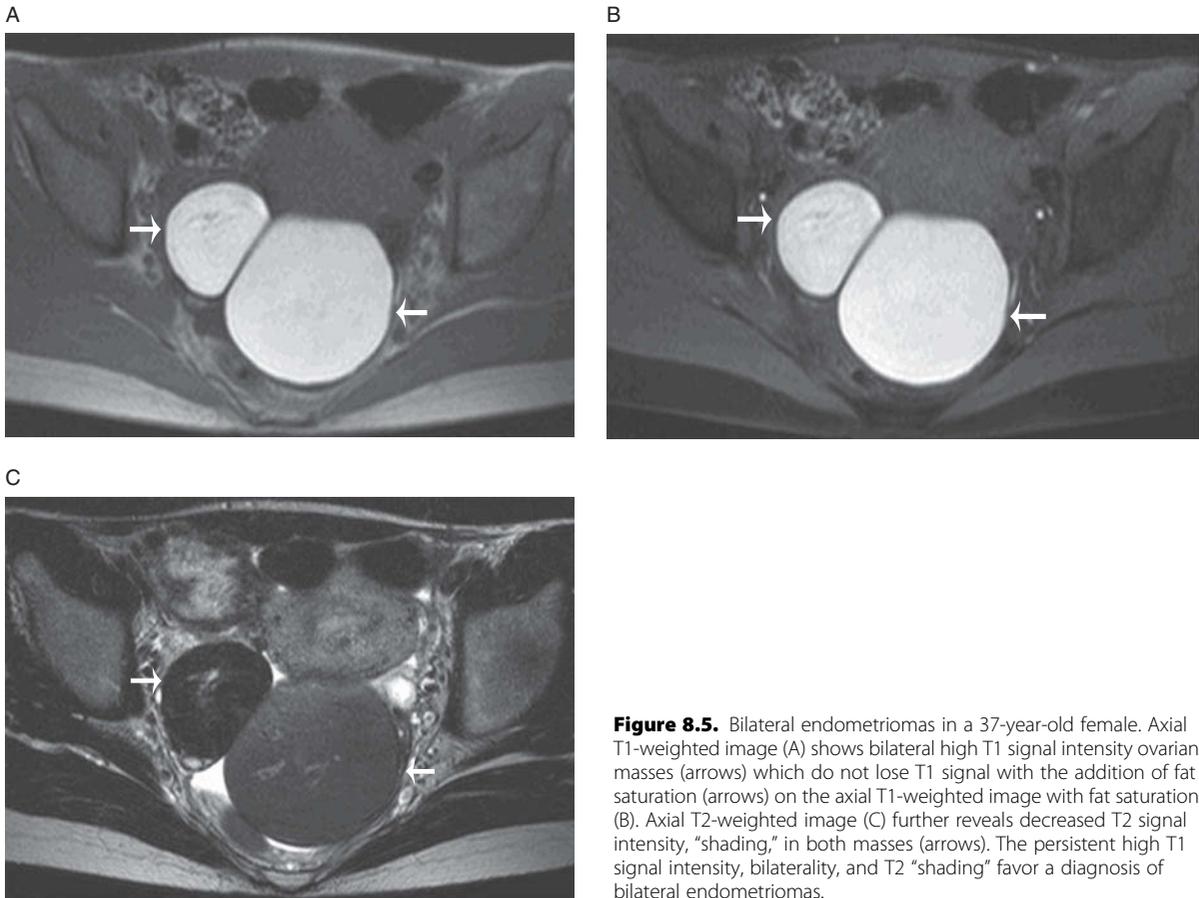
Bilateral endometriomas in a 37-year-old female. Axial T1-weighted image (A) shows bilateral high T1 signal intensity ovarian masses (arrows) which do not lose T1 signal with the addition of fat saturation (arrows) on the axial T1-weighted image with fat saturation (B). Axial T2-weighted image (C) further reveals decreased T2 signal intensity, “shading,” in both masses (arrows). The persistent high T1 signal intensity, bilaterality, and T2 “shading” favor a diagnosis of bilateral endometriomas.
